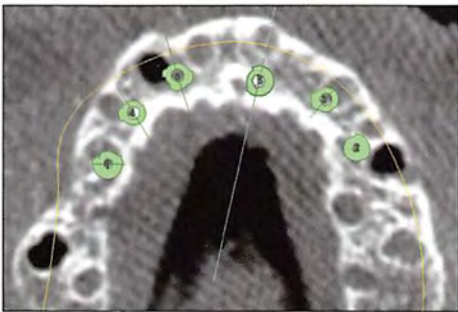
CBCT axial view showing proposed implant positions.
